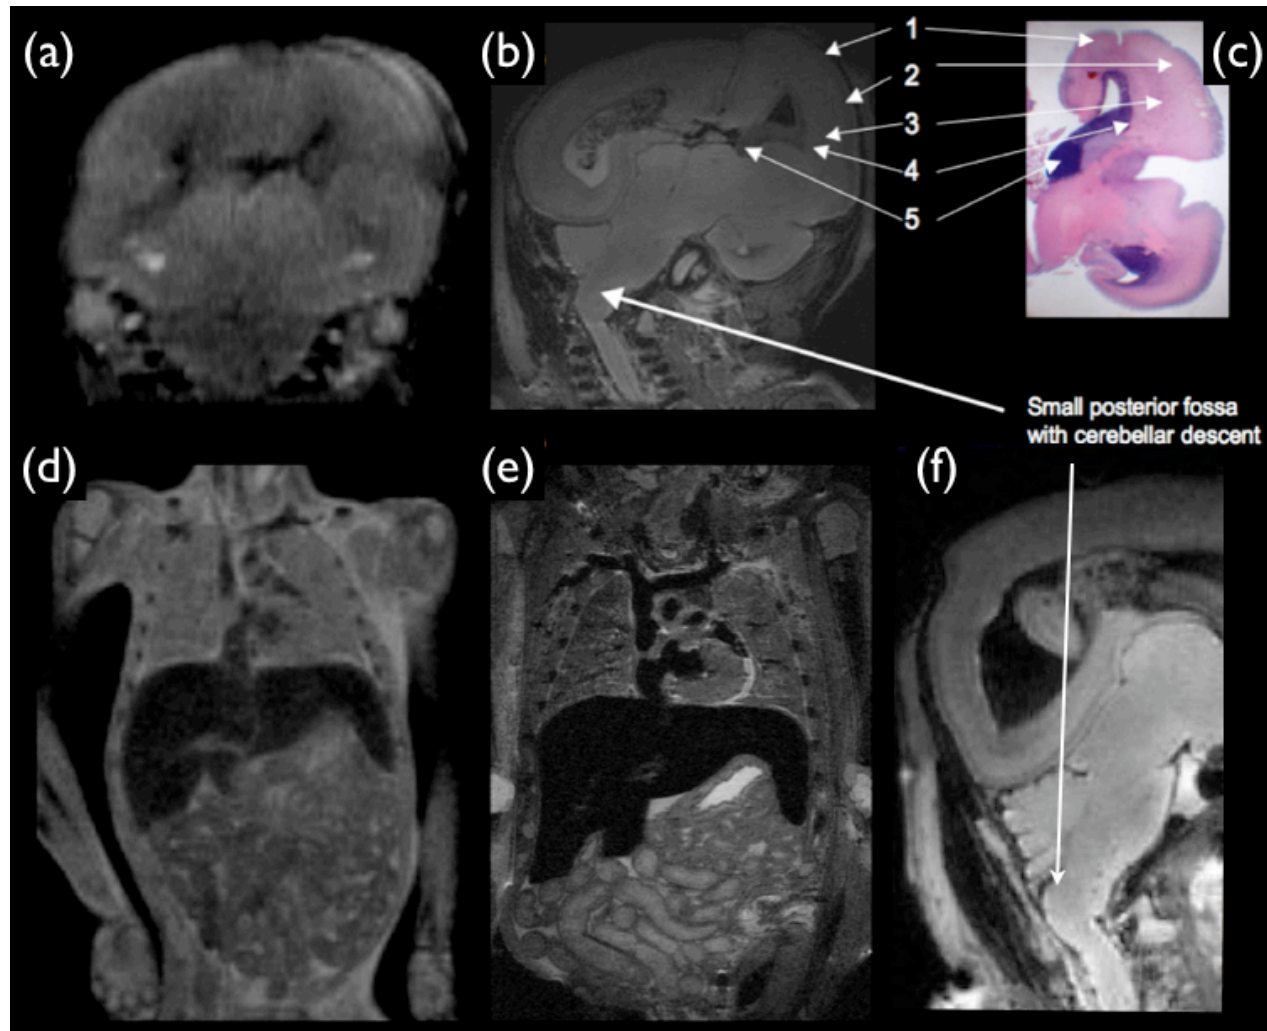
High-field 9.4T MR imaging of a fetus terminated for congenital diaphragmatic hernia and coarctation of aorta at 16 weeks (weight 64 grams).
